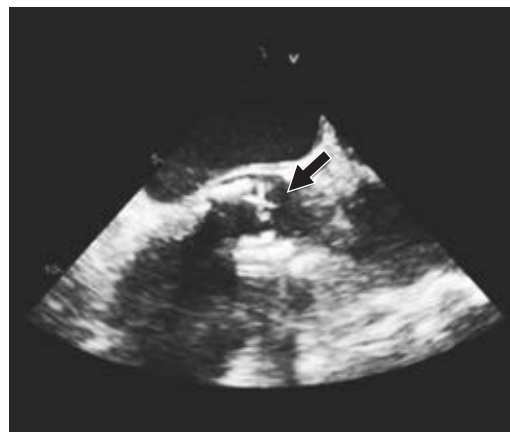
View of the prosthetic aortic valve in transesophageal echocardiography.
